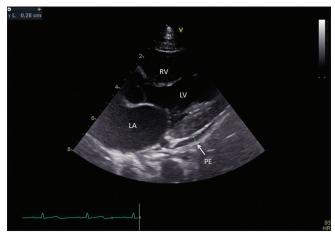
Parasternal long axis view is showing the echo-free space with dimension of 0.28 cm behind the left ventricular wall, indicating a small amount of pericardial effusion (arrow). RV: right ventricle, LA: left atrium, LV: Left ventricle, PE: pericardial effusion
